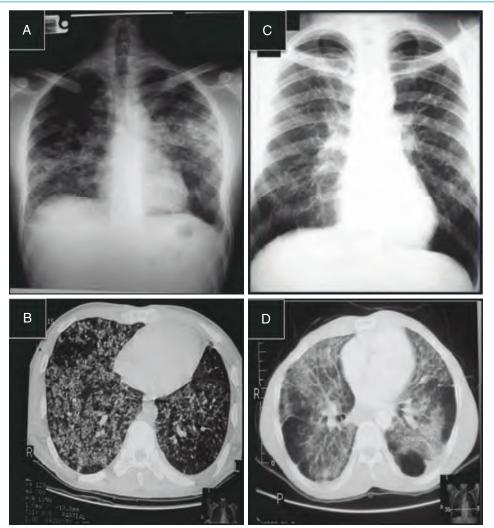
Chest radiograph and chest high-resolution computed tomography (CT) scan in paracoccidioidomycosis patients before treatment.
